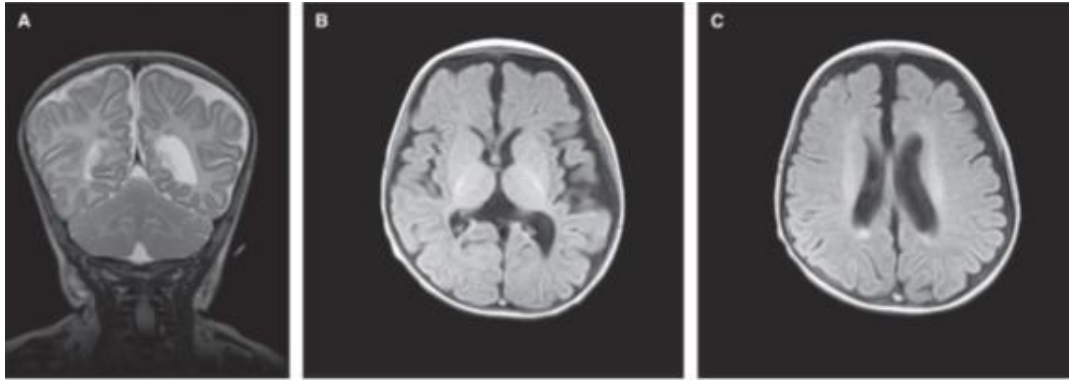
OSTM1*-Related ARO Patient Cerebral MRI. (A) Coronal T2 displaying sub-ependymal heterotopias, delayed myelination and global atrophy (B) Axial T1: sub-ependymal heterotopias (C) Axial T1 showing sub-ependymal heterotopias (Reprinted with permission from John Wiley and Sons, Journal of Bone and Mineral Research, Maranda, Chabot et al. 2008)).
